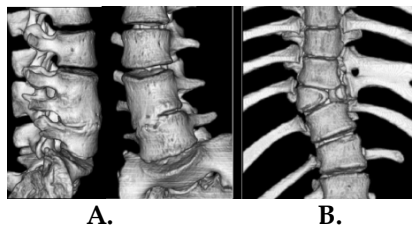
3D reconstruction by CT scan of congenital scoliosis: A. Unsegmented area between two vertebrae by loss of segmentation. B. asymmetrical vertebral bodies and fusion of ribs.
